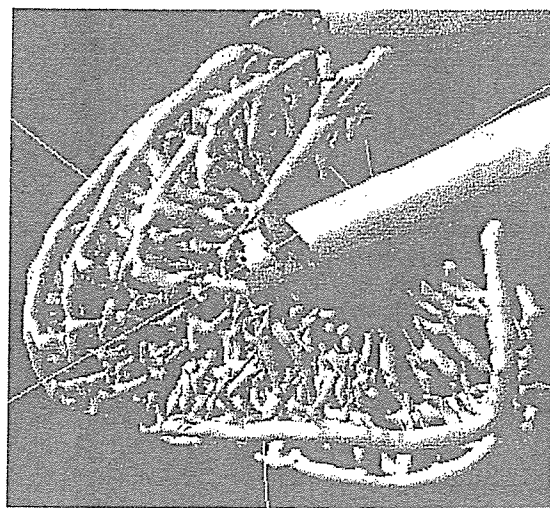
3-D image of coronary arteries constructed from x-ray CT images by Pascal.
